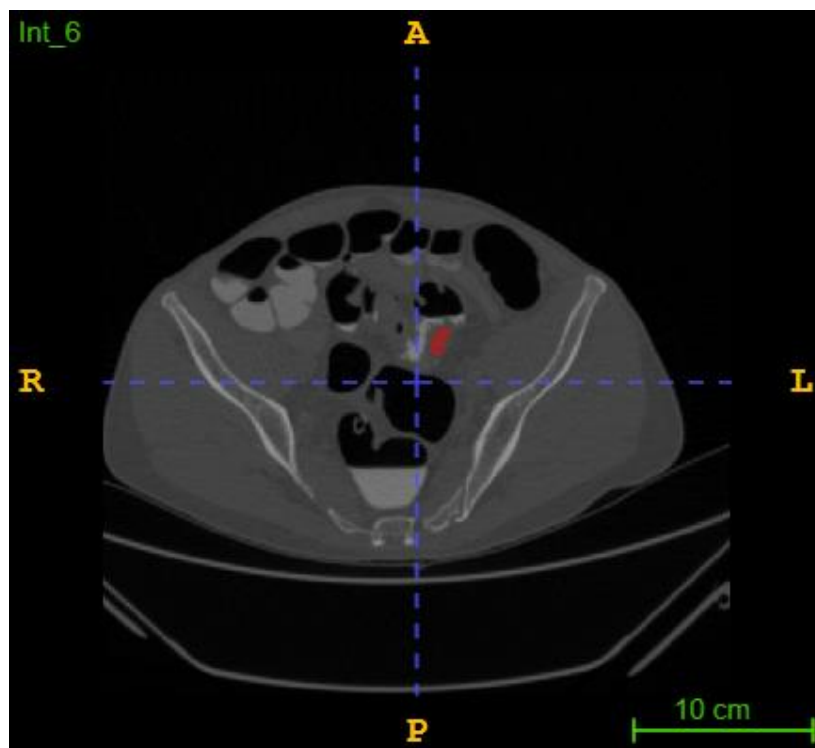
Slice extracted from a CT volume of a patient with diverticula and his corresponding manual segmentation
